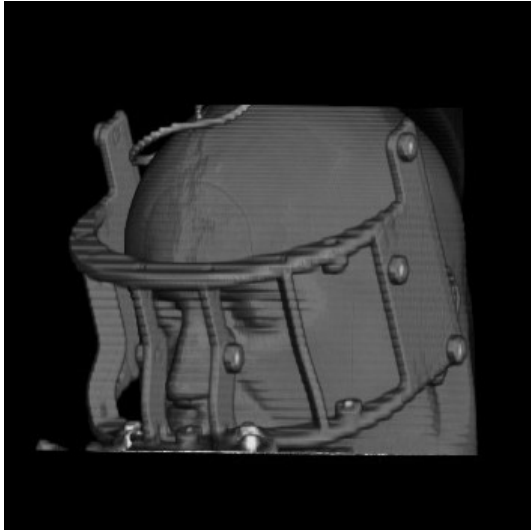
3D rendered CT image of a head with the “SIP Lab Innsbruck frame” containing the spherical markers
